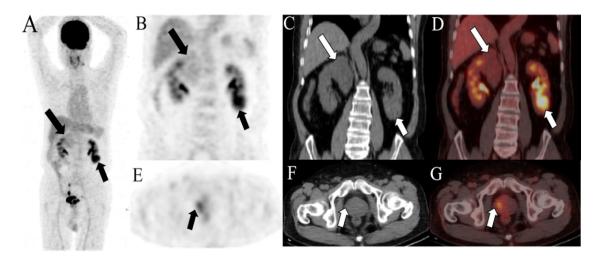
Fluorine-18-FDG PET/CT performed for baseline tumor staging demonstrates minimal 18F-FDG uptake in the right renal mass in the upper pole of the kidney with SUVmax of 2.99 [black long arrow in A, maximum intensity projection (MIP) imaging; long arrow in B, PET imaging; C, CT imaging; and D, fusion imaging] and intense uptake in the mass in the left lower pole of the left kidney with SUVmax of 8.12 (black short arrow in A, MIP imaging; short arrow in B, PET imaging; C, CT imaging; and D, fusion imaging). The right side of the prostate gland has increased 18F-FDG uptake with SUVmax of 4.19 but CT showed no abnormal density (arrow in E, PET imaging; F, CT imaging; and G, fusion imaging).
